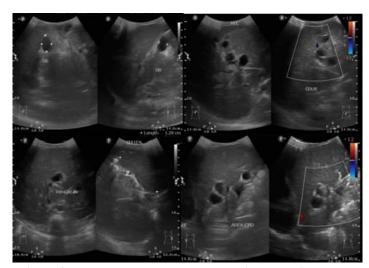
Ultrasonography showed multiple cysts in the liver Magnetic Resonance Cholangiopancreatography (MRCP)
